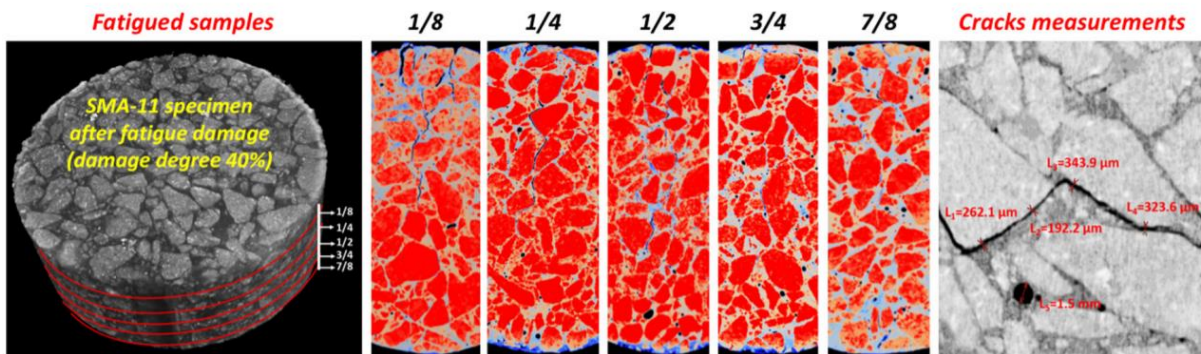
20 Computed Tomography (CT) images of crack healing for an SMA-11 mixture [94]
